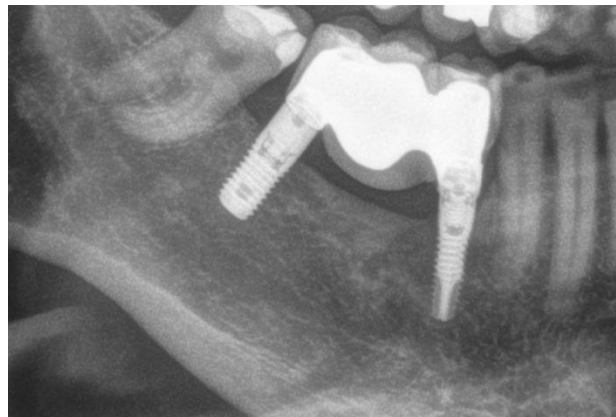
X-ray at 10 years. The stability of the treatment can be observed
